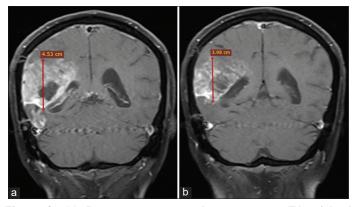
(a) Pre-treatment coronal post-contrast T1-weighted image showing heterogeneously enhancing tumor, volume 58.42 cc; (b) Post-treatment (day 20) coronal post-contrast T1-weighted image showing reduction in the tumor size volume 36.07 cc and degree of enhancement of the tumor
